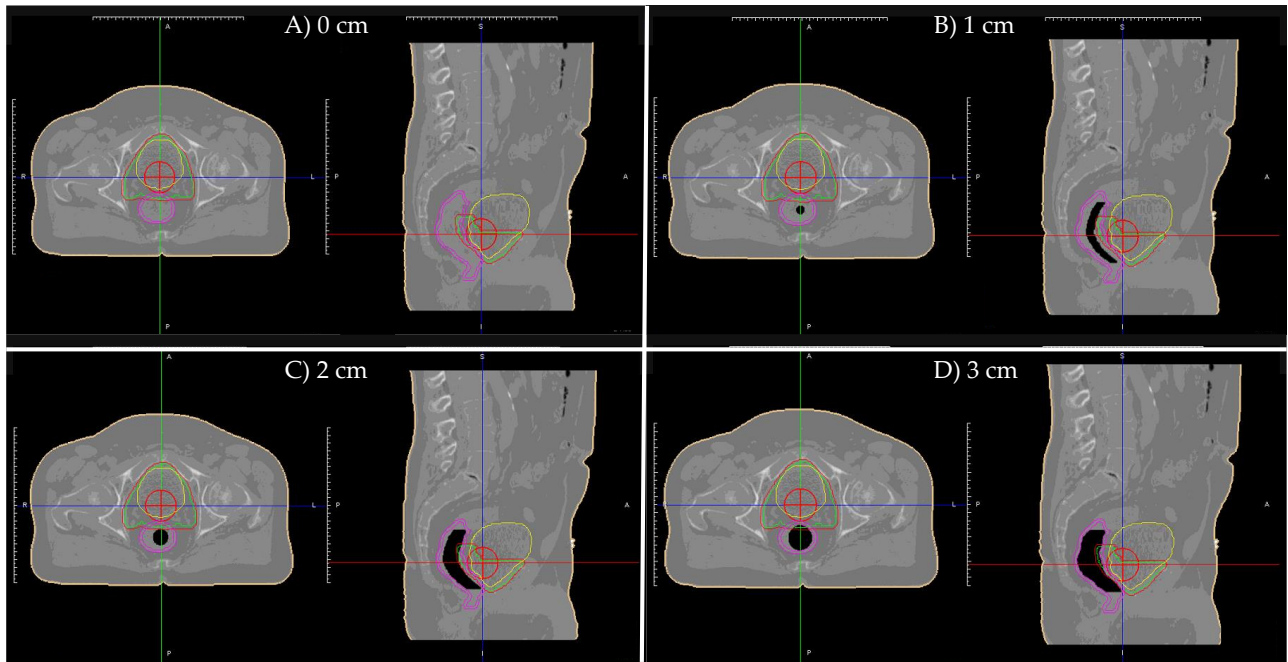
Patient A's planning CT electron density maps with artificial tubular air cavities of diameters: (A) 0 cm; (B) 1 cm; (C) 2 cm; and (D) 3 cm. Planning CT contours displayed: Red—planning target volume (PTV); Green—clinical target volume (CTV); Yellow—bladder; Pink—rectum/rectal wall; Red cross—iso-center
